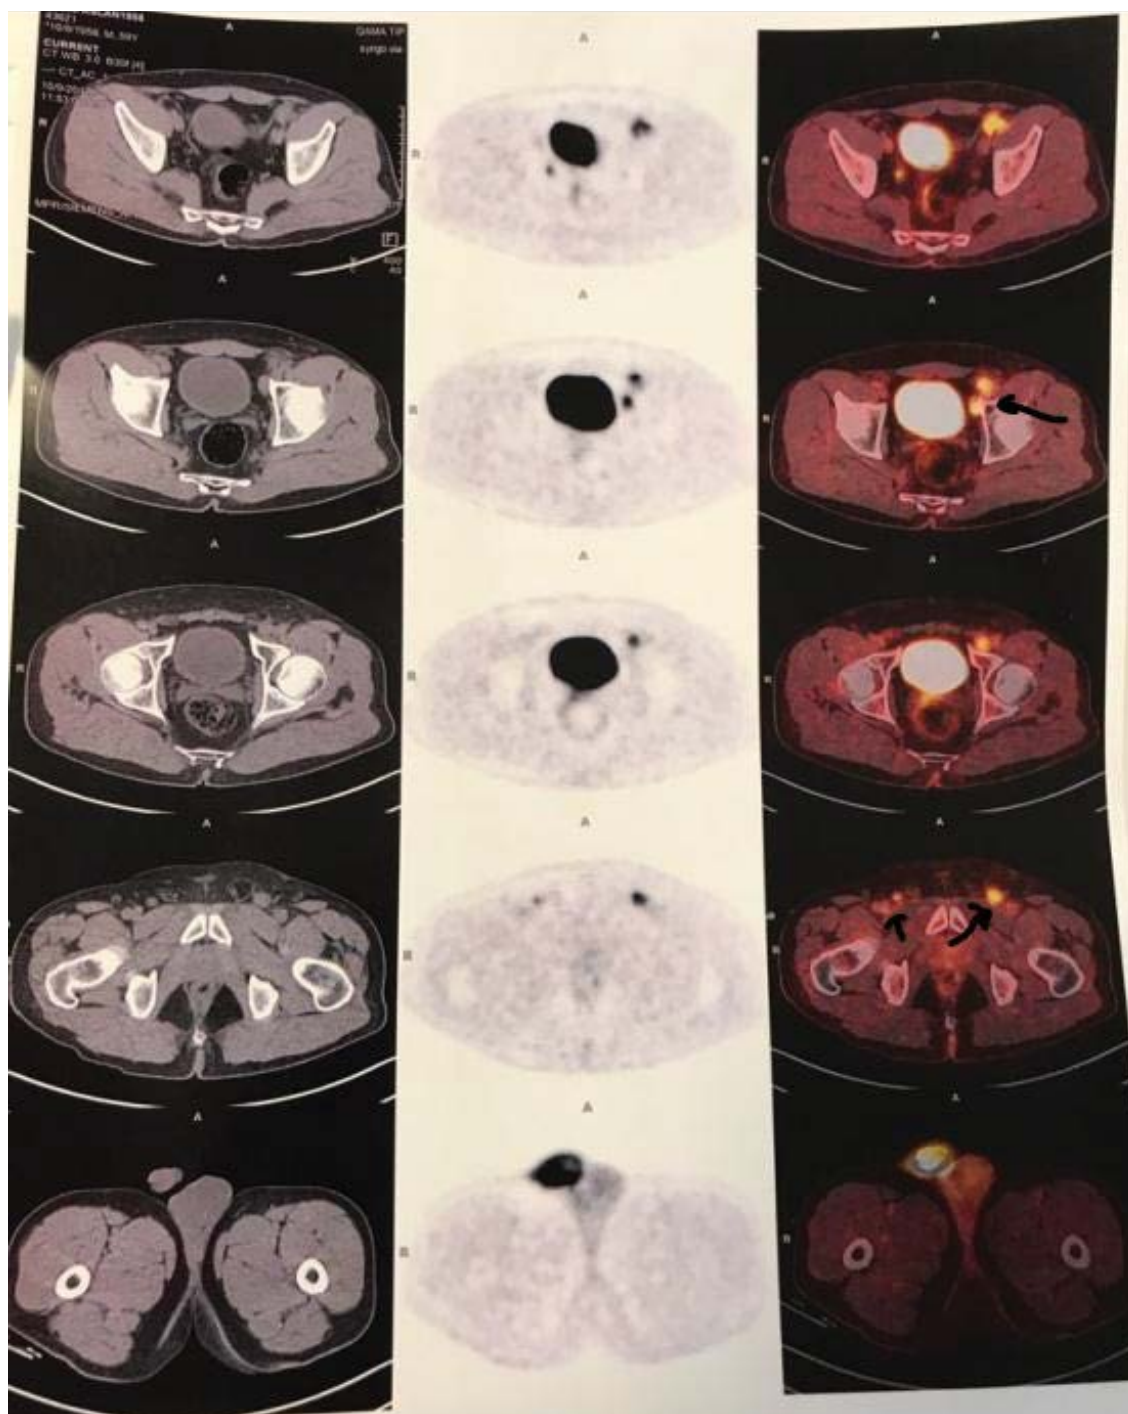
PET/CT scan (positive inguinal lymph nodes).
